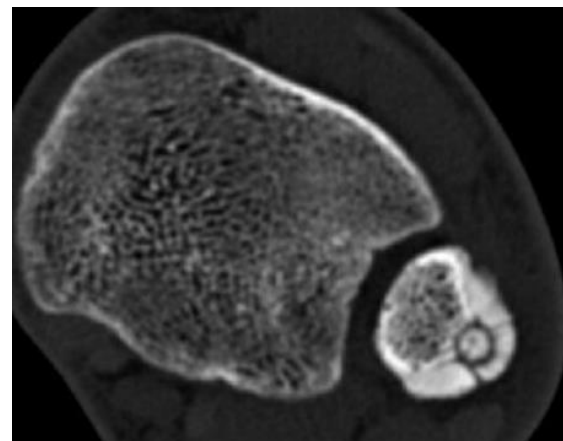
CT Scan shows an area of central translucency measuring less than 1.5 cm in diameter, in cortex surrounded by dense sclerosis
